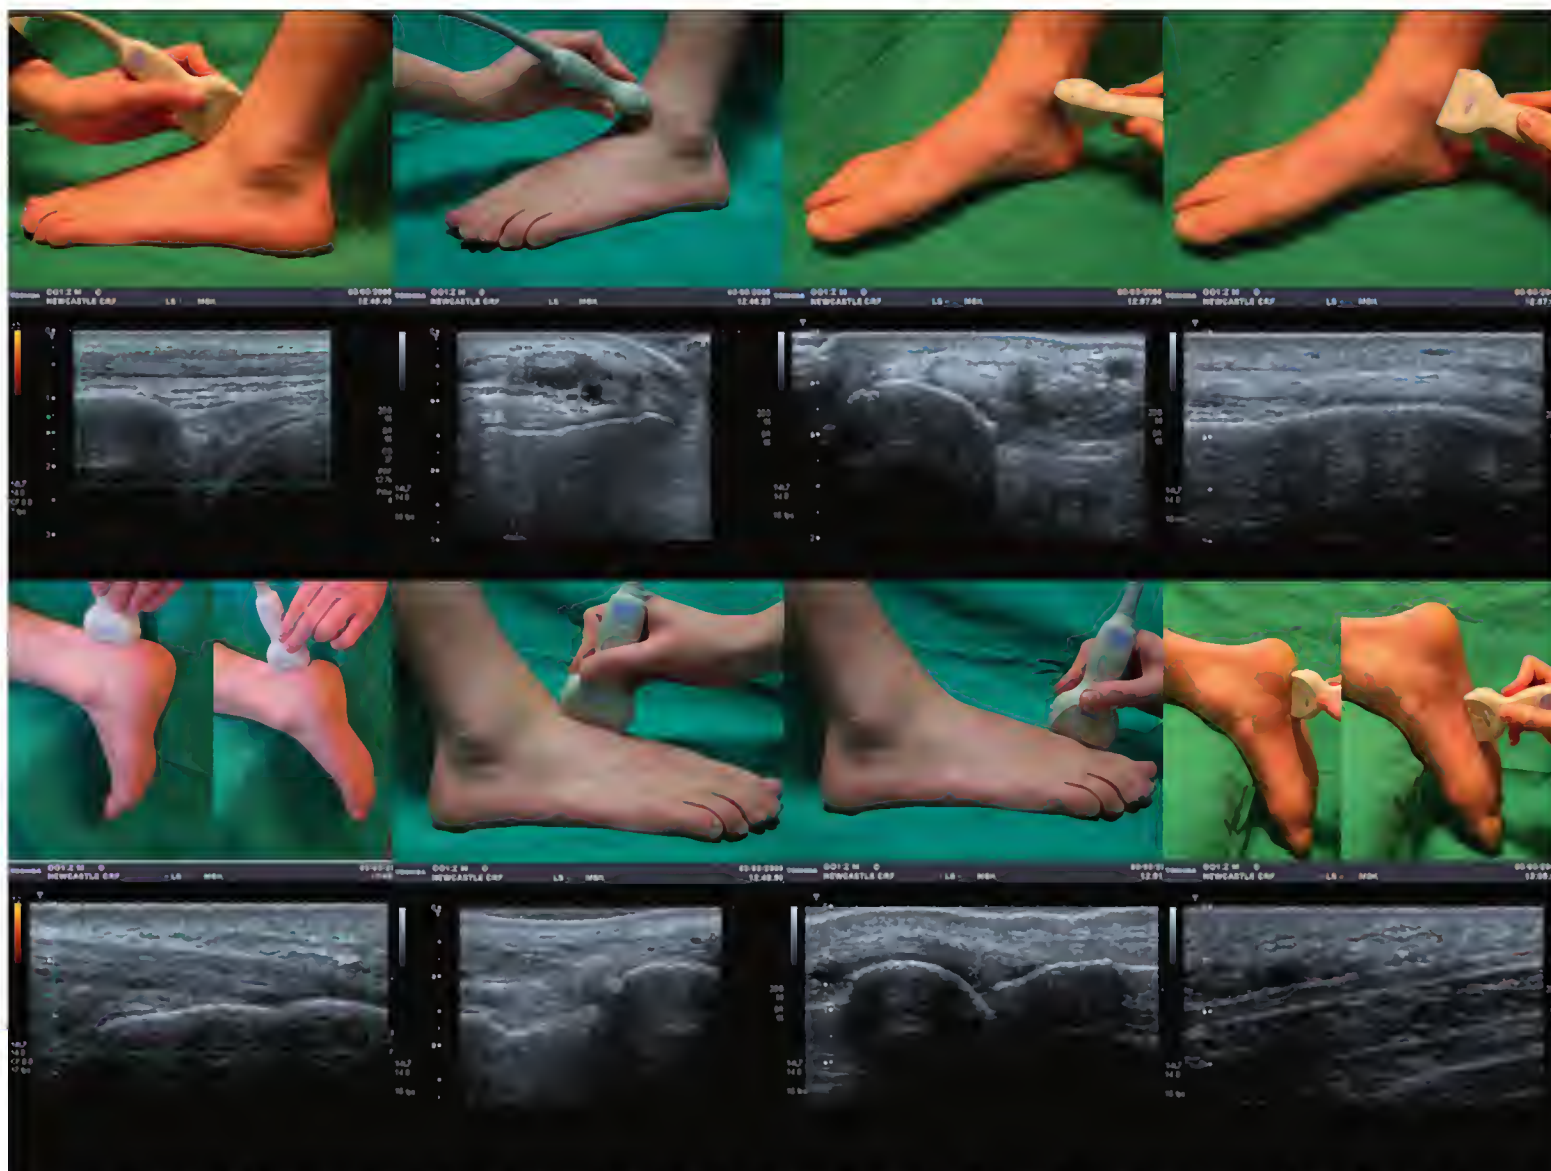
Ultrasound of the foot and ankle in the rheumatology clinic. After history taking and physical examination the rheumatologist can immediately apply the ultrasound probe directly to the symptomatic anatomic area on the foot and ankle, which allows immediate confirmation of the clinical diagnosis and prescription of therapy. The panel of images shows multiple probe positions and corresponding ultrasound images demonstrating the flexibility of this technique.
